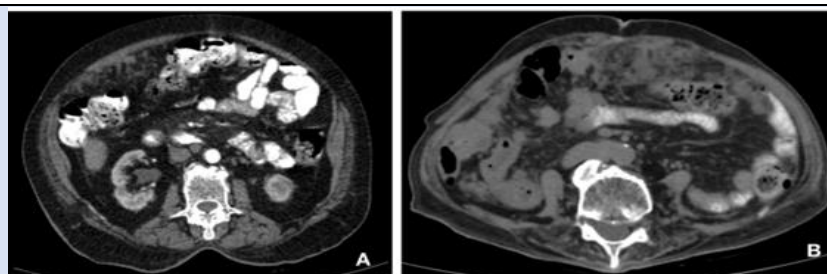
A - CT abdomen with contrast arterial phase axial section image showing omental nodules in right hypochondrium. B - CT abdomen plain axial section image showing omental caking in epigastric and umbilical region in a 55-year-old female patient with known history of right ovarian carcinoma
